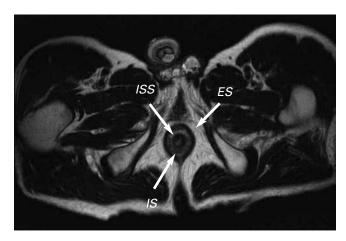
Axial T2-weighted MR image shows the normal anatomy of the perianal region: ES = external sphincter, IS = internal sphincter, and ISS = intersphincteric space.
